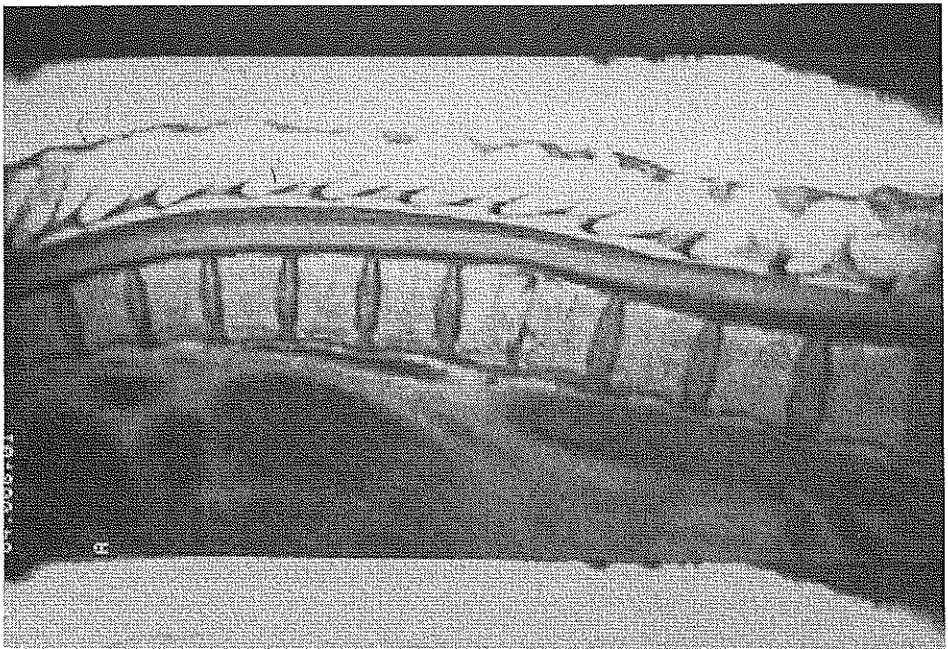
MRI is showing vertebral body defect in the surface of the disk space after three months of treatment epidural abscess and recovery of the abscess.
